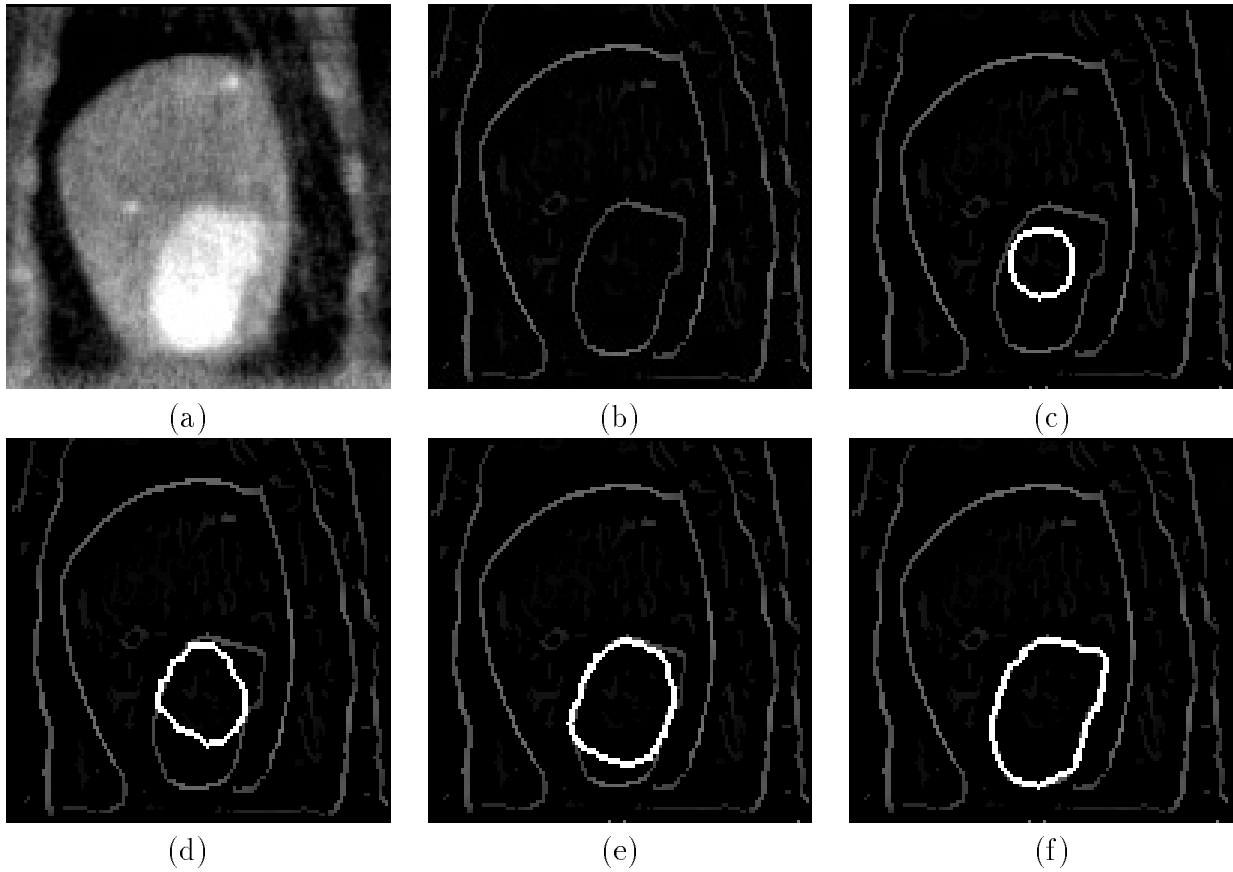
Intensity and edge detected CT image slice of left ventricle. (a) Intensity image XZ plane slice 91. (b) Edge detected image. (c) Cross section of initial balloon model. (d)-(f) Cross section of balloon deforming to left ventricle.
